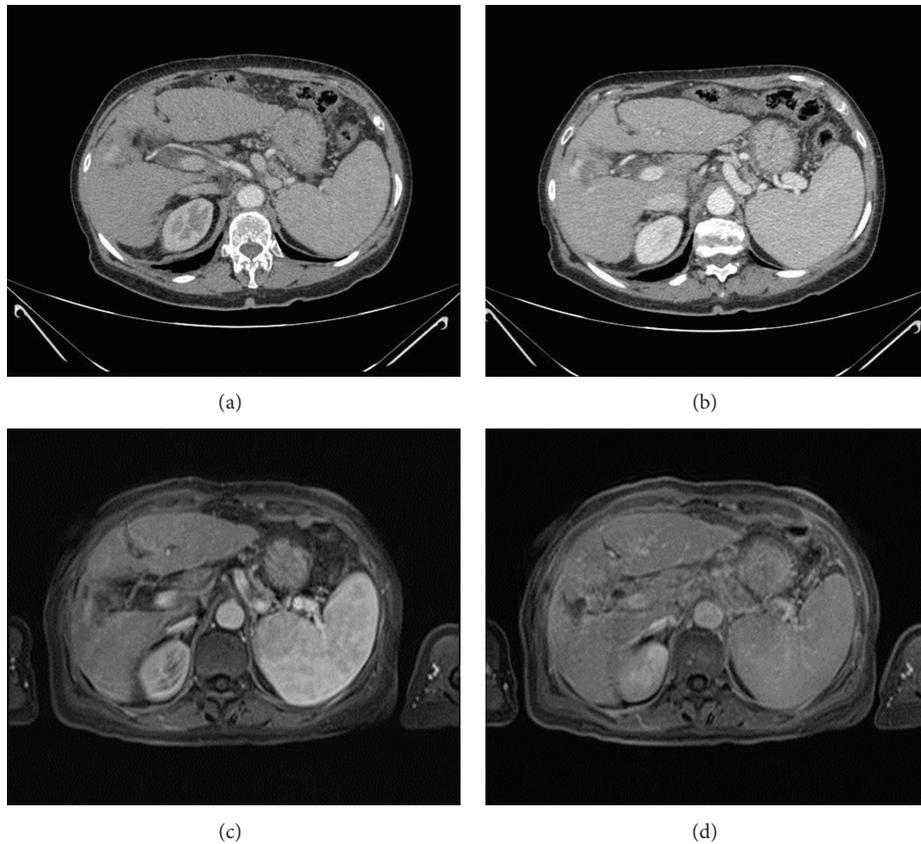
66-year-old woman with an arteriovenous shunt after RFA for HCC. (a) Arterial-phase CT scan at 3-month followup. Enhancing tissue close to the ablated area, incorrectly diagnosed as residual tumor. (b) Portal-phase CT scan at 3-month followup. Enhancing tissue close to the ablated area, incorrectly diagnosed as residual tumor. The lack of washout should have raised the suspicion of a benign finding. (c) Arterial-phase MR image at 3-month followup. Enhancing tissue close to the ablated area, incorrectly diagnosed as residual tumor. (d) Portal-phase MR image at 3-month followup. The lack of wash-out and the same parenchymal enhancement identify the lesion as benign.
